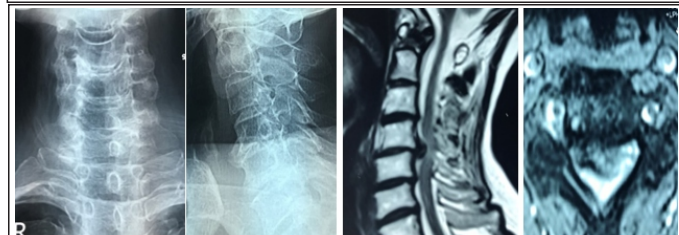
Pre-operative X-ray of cervical spine A/P and lateral view and magnetic resonance imaging of the cervical spine.
